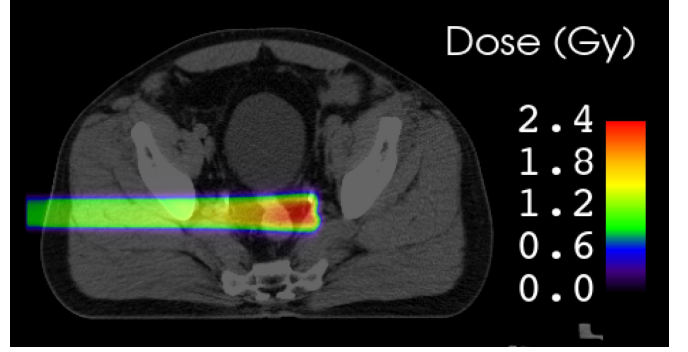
Dose deposited by the reference SOBP overlaid on the prostate CT
